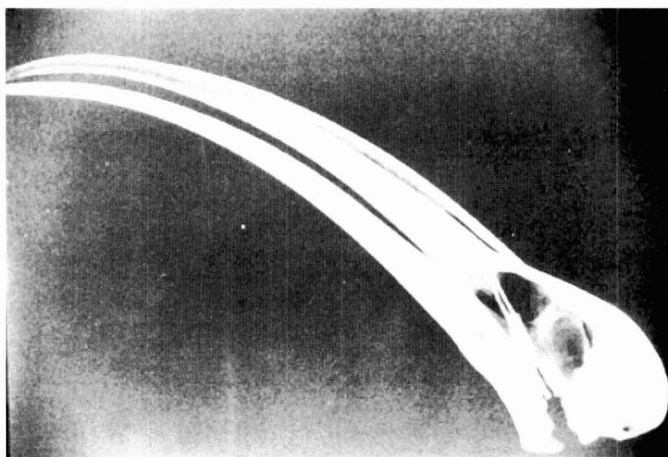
Lateral radiography of a dry cranium of the *Threskiornis aethiopicus*.
